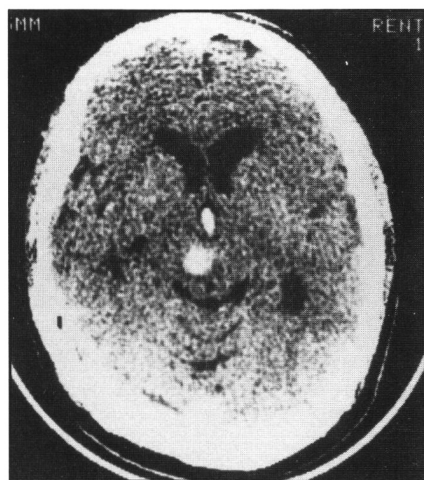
Admission CT scan of patient 1 showing right-sided mesencephalic tegmental hemorrhage, intraventricular hemorrhage and dilated lateral ventricles. Additional sections and scans on subsequent days revealed significant intraventricular hemorrhage and quadrigeminal plate cisternal involvement, respectively.
